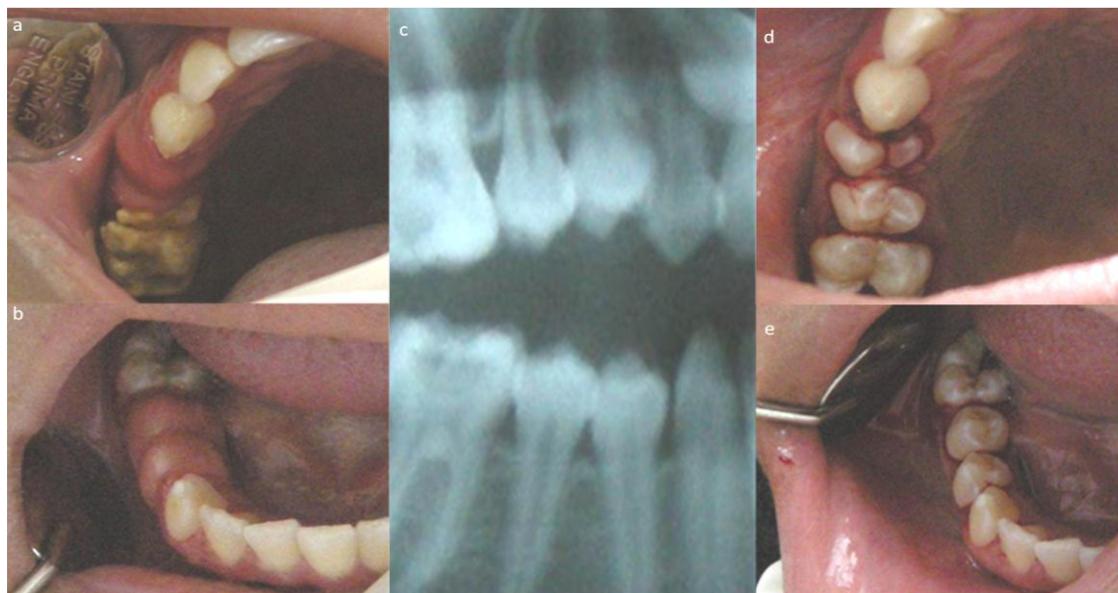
Clinical photographs showing the pre-operative (a & b) and post-operative (d & e) soft tissue impacted mandibular and maxillary premolars along with a segmental radiograph shows premolars in infra occlusion (c).
